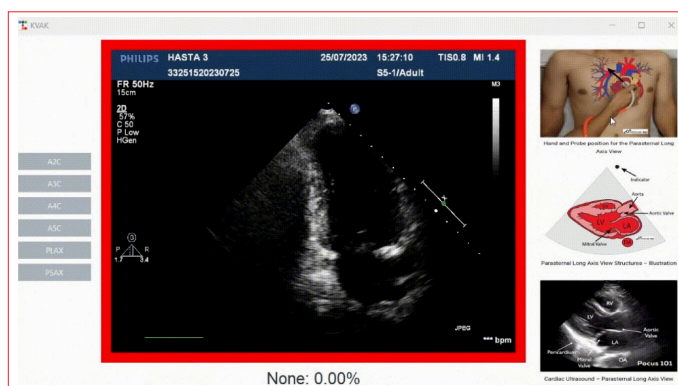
A2C measurement to improve visualization and user-friendliness, we developed a dedicated application for our model. In this application, the user can select the desired echocardiographic view using the buttons on the left panel. On the right side, we included reference images to assist students while reviewing the selected view. The central area displays the real-time echocardiographic image. A guiding frame appears around the image: green if the correct view is approached, and red if the current view is far from the target, helping guide the user toward the correct position. At the bottom of the interface, the model's prediction and its confidence percentage are displayed. The video format of the file could not be loaded. A measurement video is available. It can be sent upon request.
